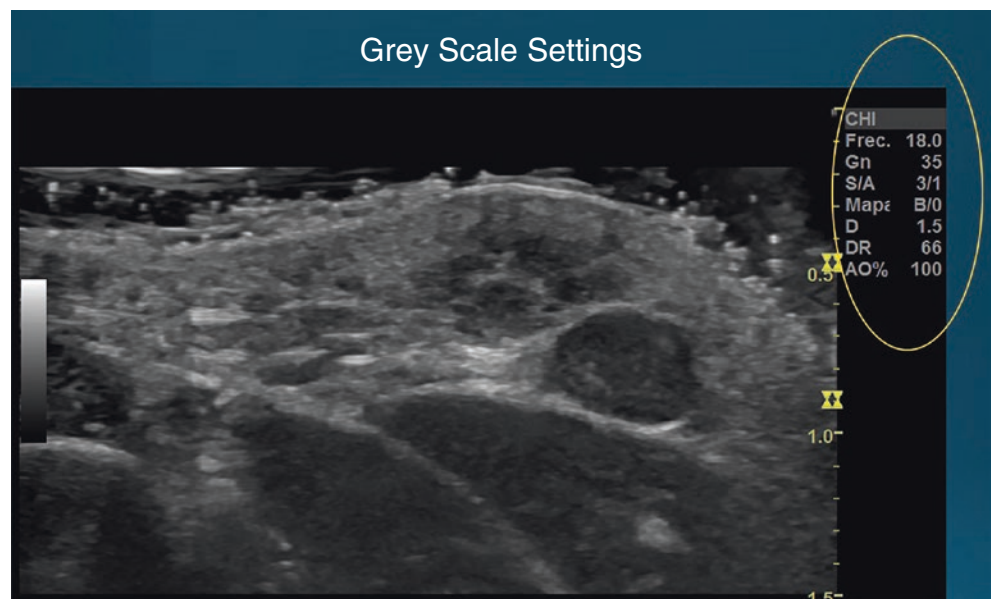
An example of grey scale setting for dermatologic ultrasound studies.
